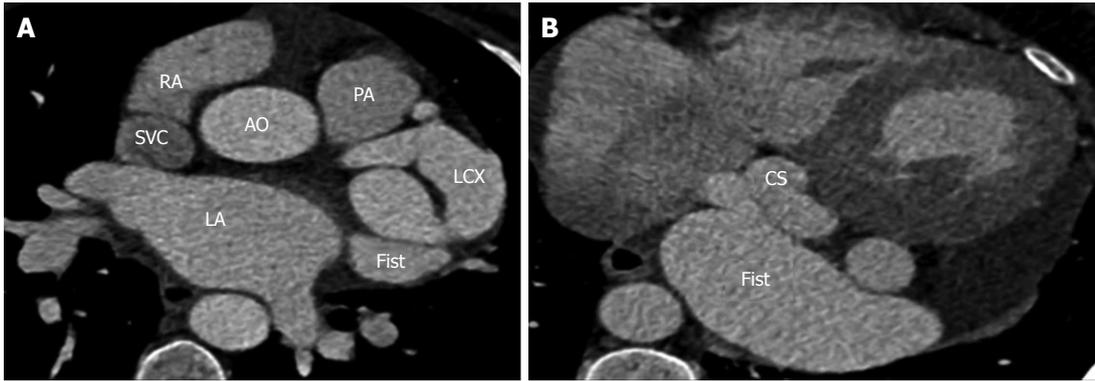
Left circumflex coronary artery to coronary sinus fistula. A: Axial coronary computed tomography angiography (CTA) shows dilated, tortuous left circumflex coronary artery (LCX) due to a LCX fistula (Fist); B: Axial coronary CTA shows the LCX Fist drains into the coronary sinus (CS). PA: Pulmonary artery; AO: Aorta; LA: Left atrium; RA: Right atrium; SVC: Superior vena cava.
